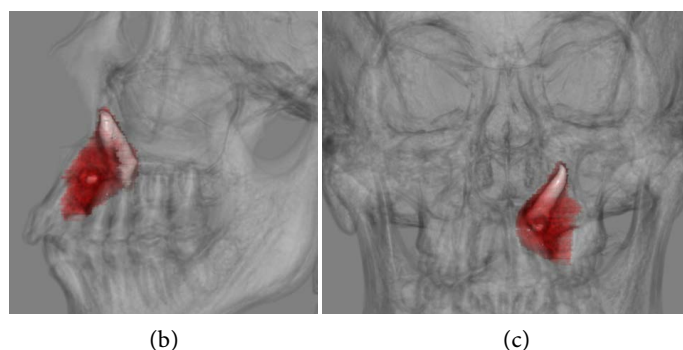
CT images were used to segment the maxillary cyst. The examiner manually surface-detected maxillary cysts and created its visualization 3D models of them.
